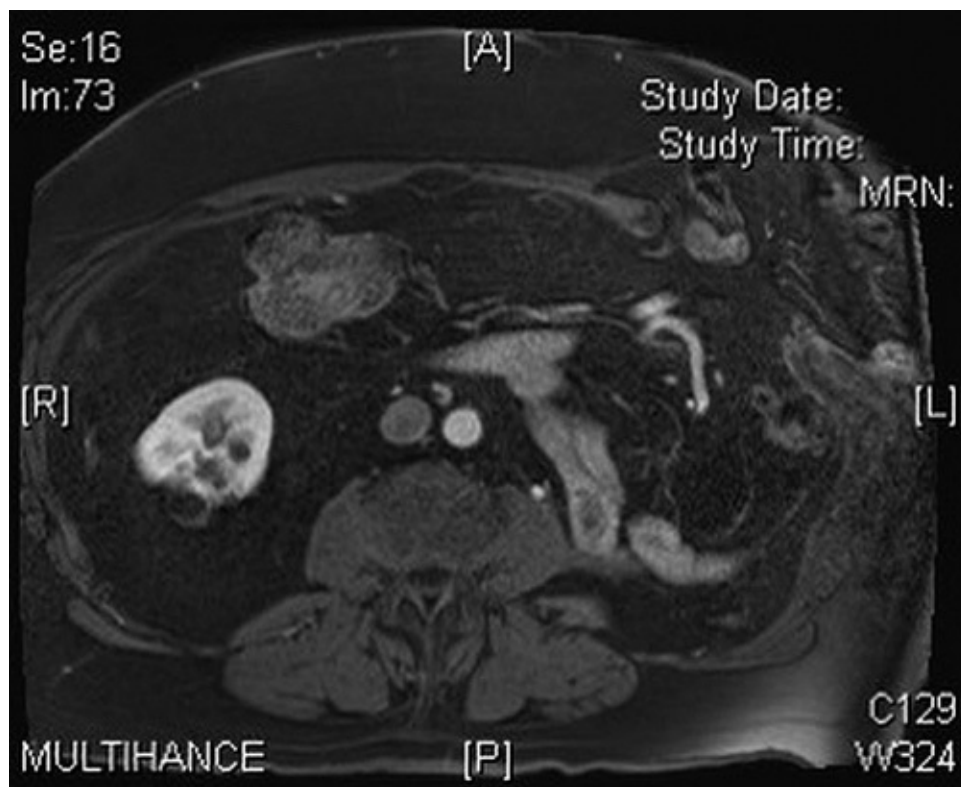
• CT Scan of a patient with a flank hernia.
